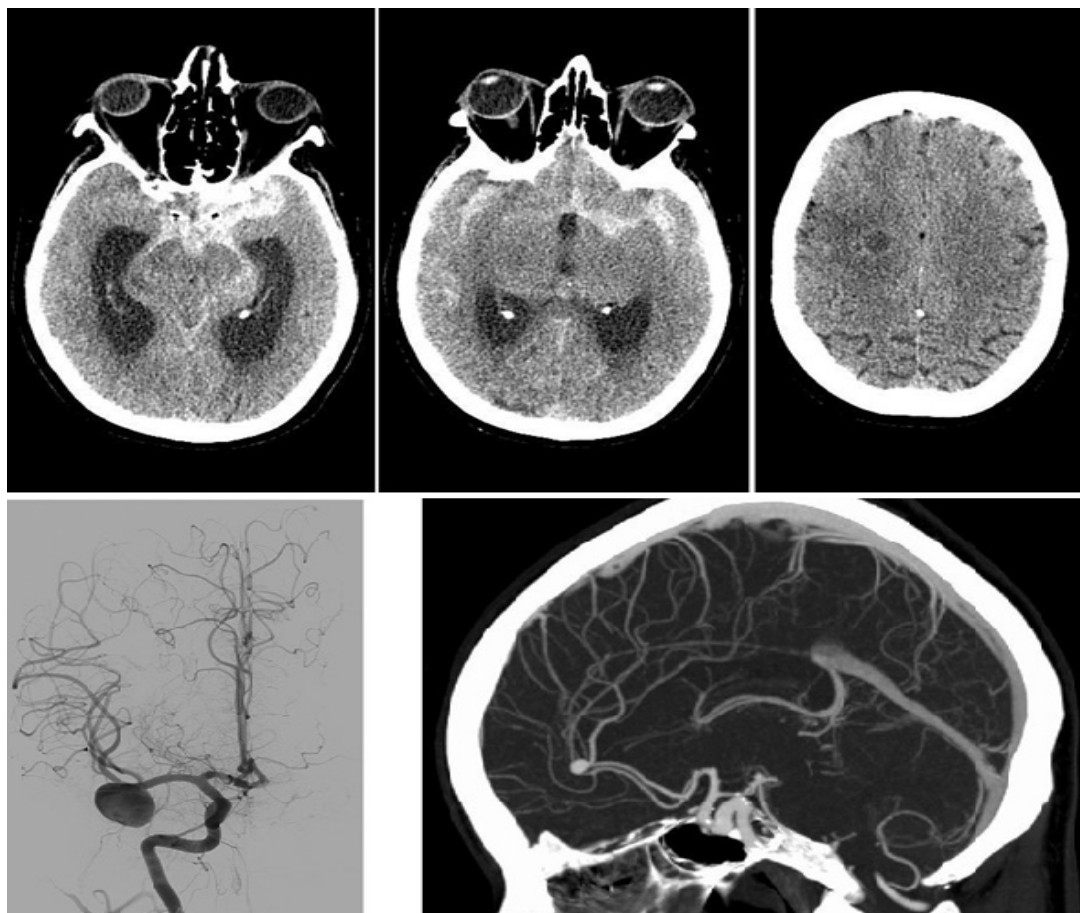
Images of SAH in CT (Above) and cerebral Arteriography with aneurysm of middle cerebral artery (Down).
